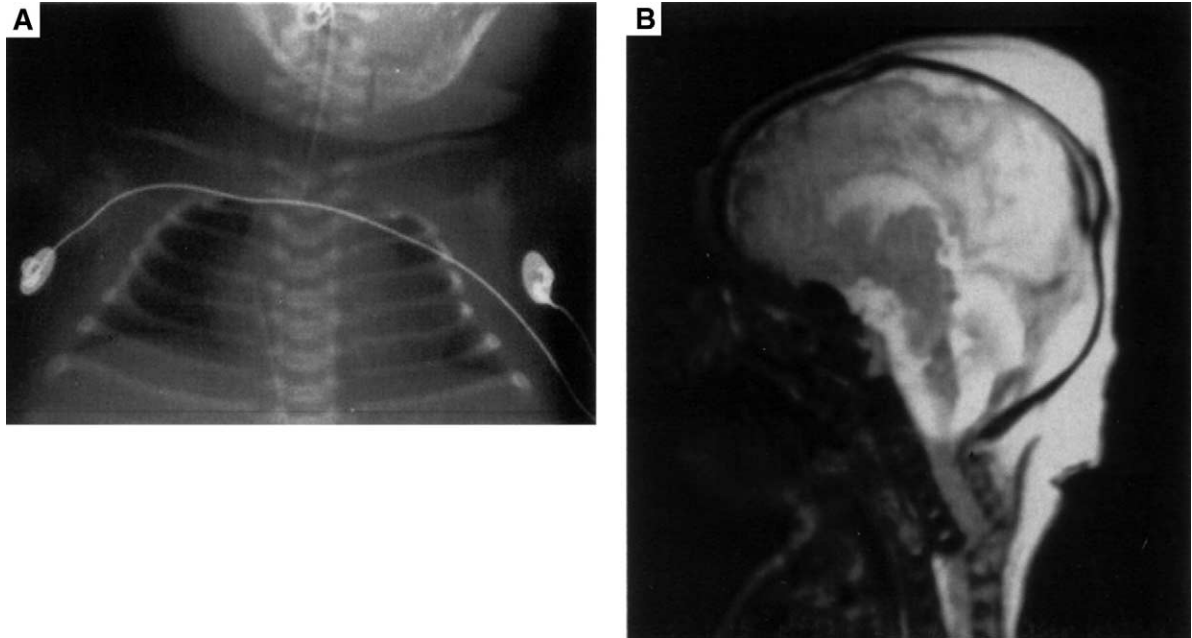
(A). Radiograph showing disruption of cervical spine. Note the shadow of the endotracheal tube crossing the chasm in the cervical spine. (B) Magnetic resonance image showing displacement of cervical spine. Courtesy of Dr. Michael Speer, with permission.
